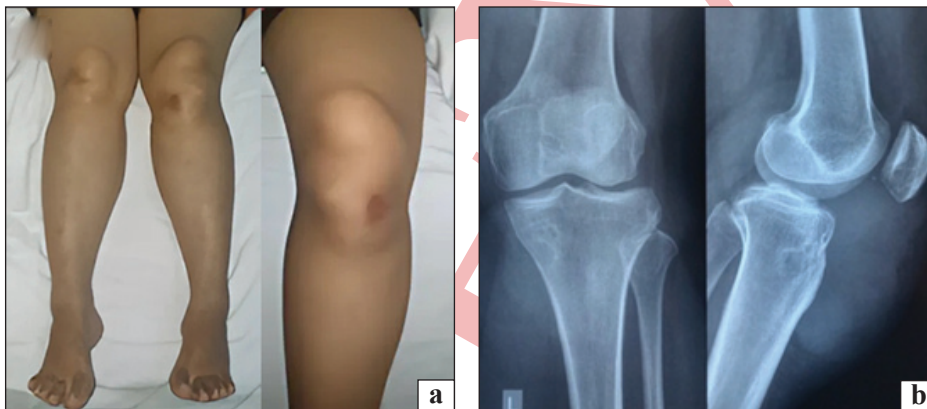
Clinical Picture of both lower leg and Right Knee from anterior (a), and X-Ray findings of the left knee lateral (b)
